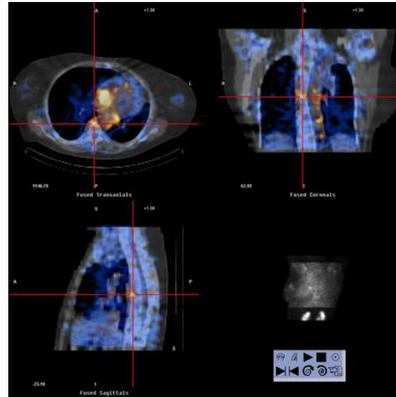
Patient with Wegener's granulomatosis. Transaxial, coronal, and sagittal fused SPECT/CT sections showing mild ^{111}In -Biotin uptake in dorsal vertebra (false-positive finding)
